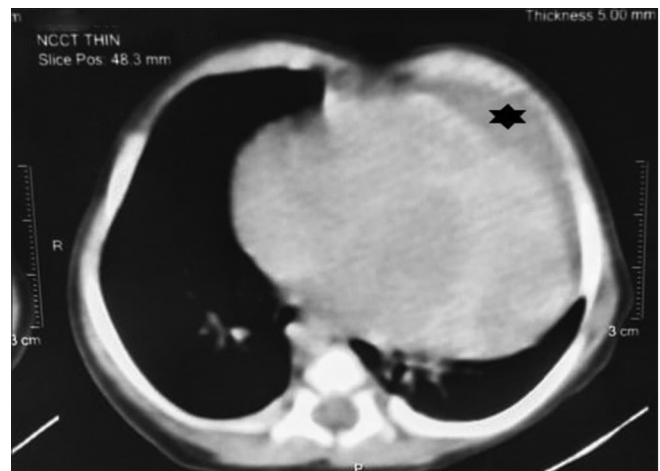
Cardiac CT revealing heterogeneous well-defined soft-tissue density mass lesion on the left side of the pericardium (marked by *). CT: Computerized tomography
